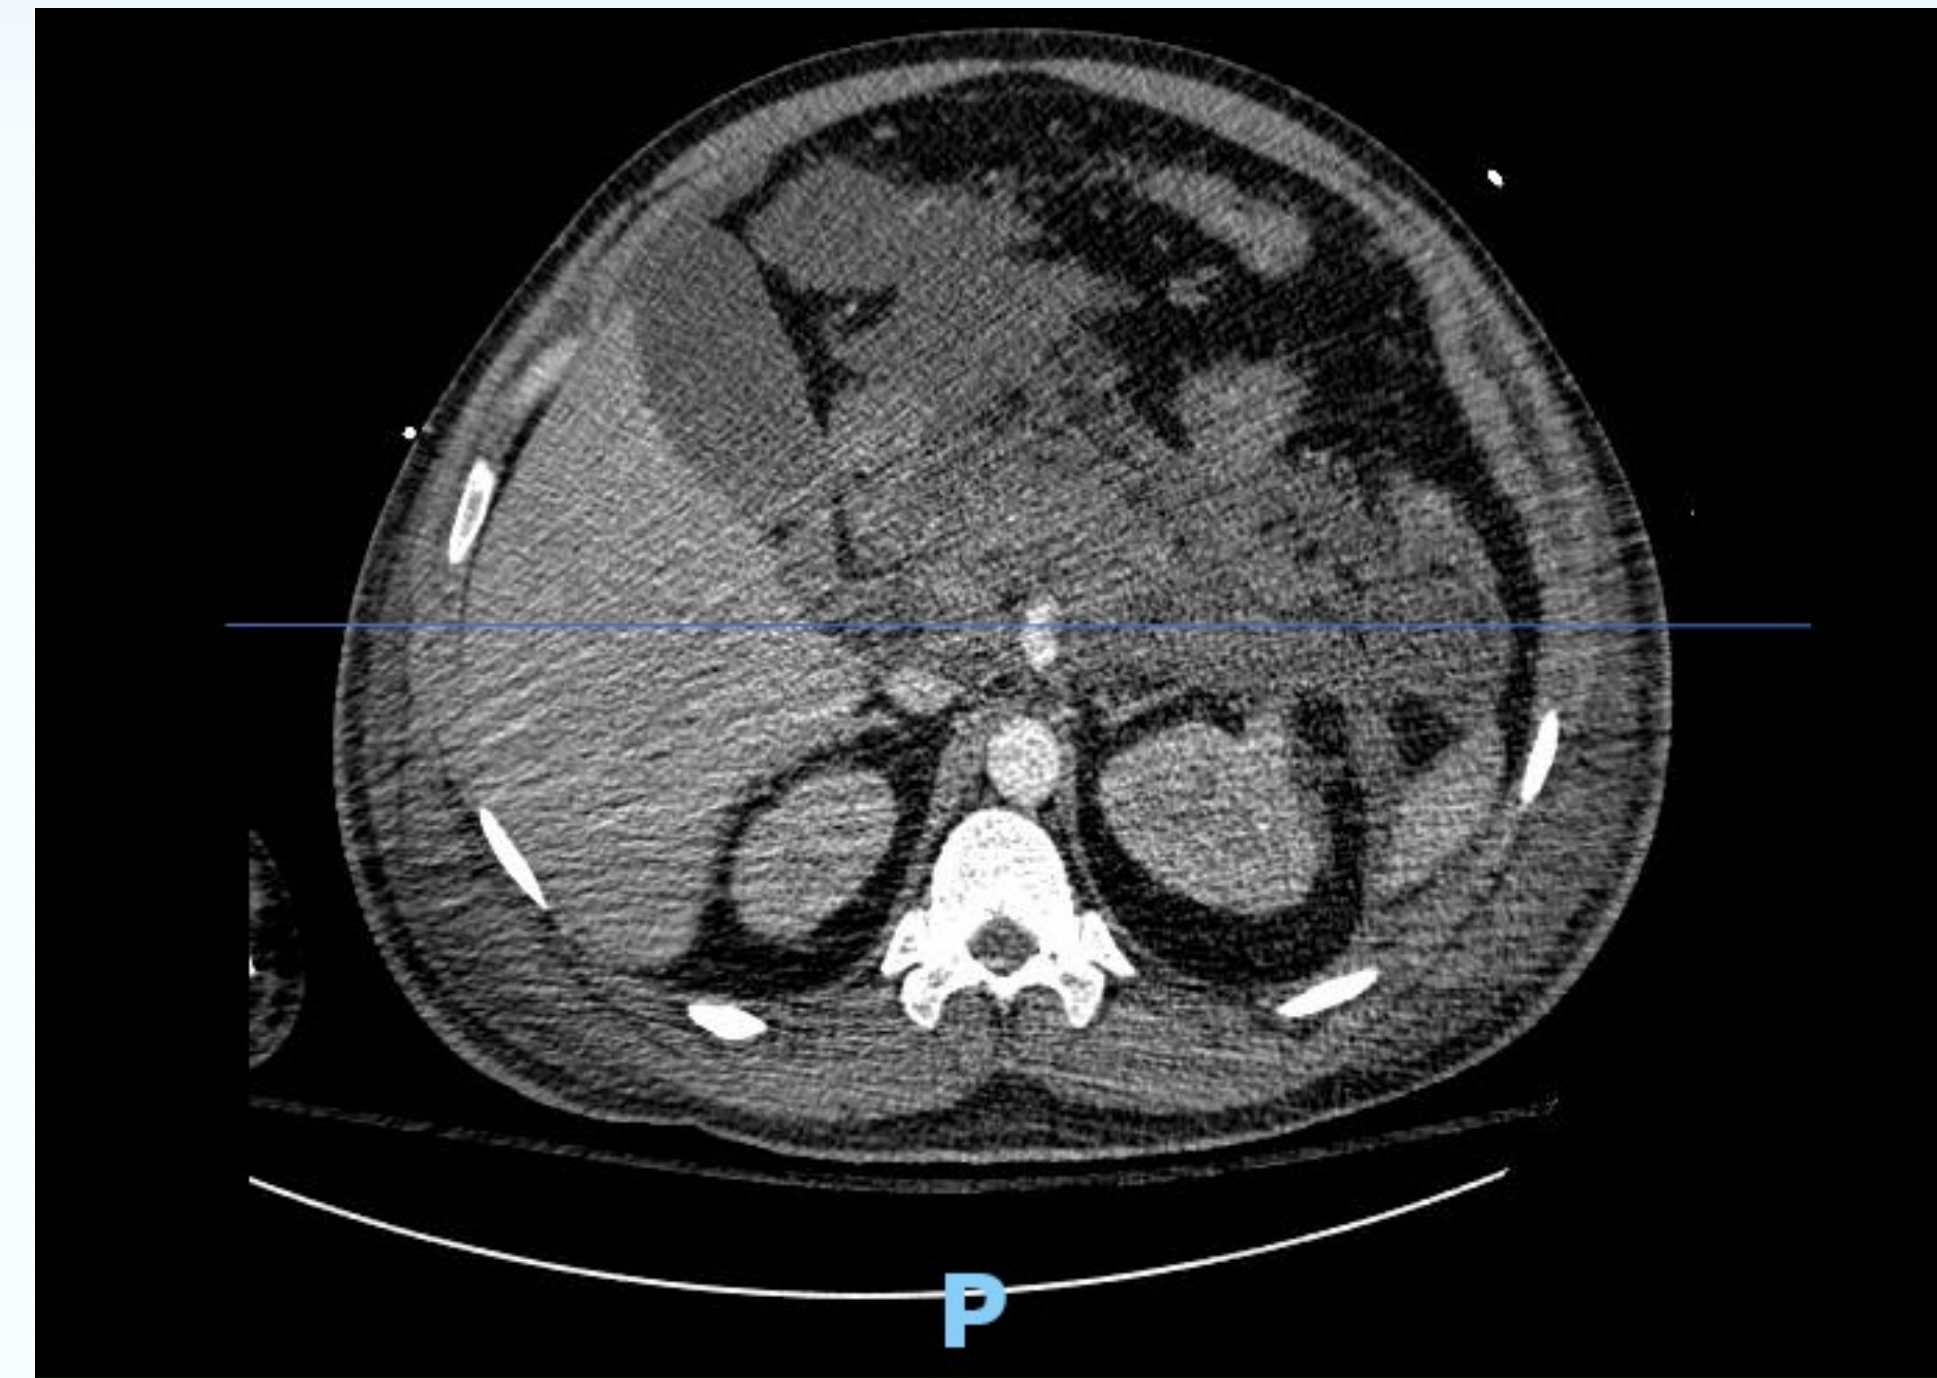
Abdominopelvic CT scan with IV contrast with multiple non-enhancing homogeneous fluid collections which may represent acute peripancreatic fluid collections, the largest measuring 10.9 cm AP x 11.5 cm transverse x 4.8 cm cc.
